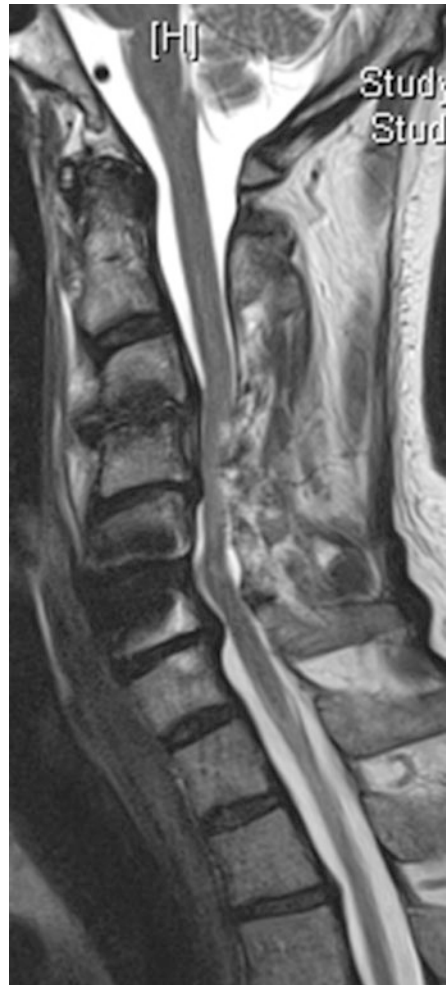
Cervical spondylotic myelopathy: Sagittal T2-weighted MR image showing a multisegmental degenerative narrowing of the spinal canal at cervical level with depleted subarachnoid space and a hyperintense intramedullary signal reflecting myelopathy with maximum at level C4/C5 in a 50-year-old patient with tetraparesis C3 (AIS D)
